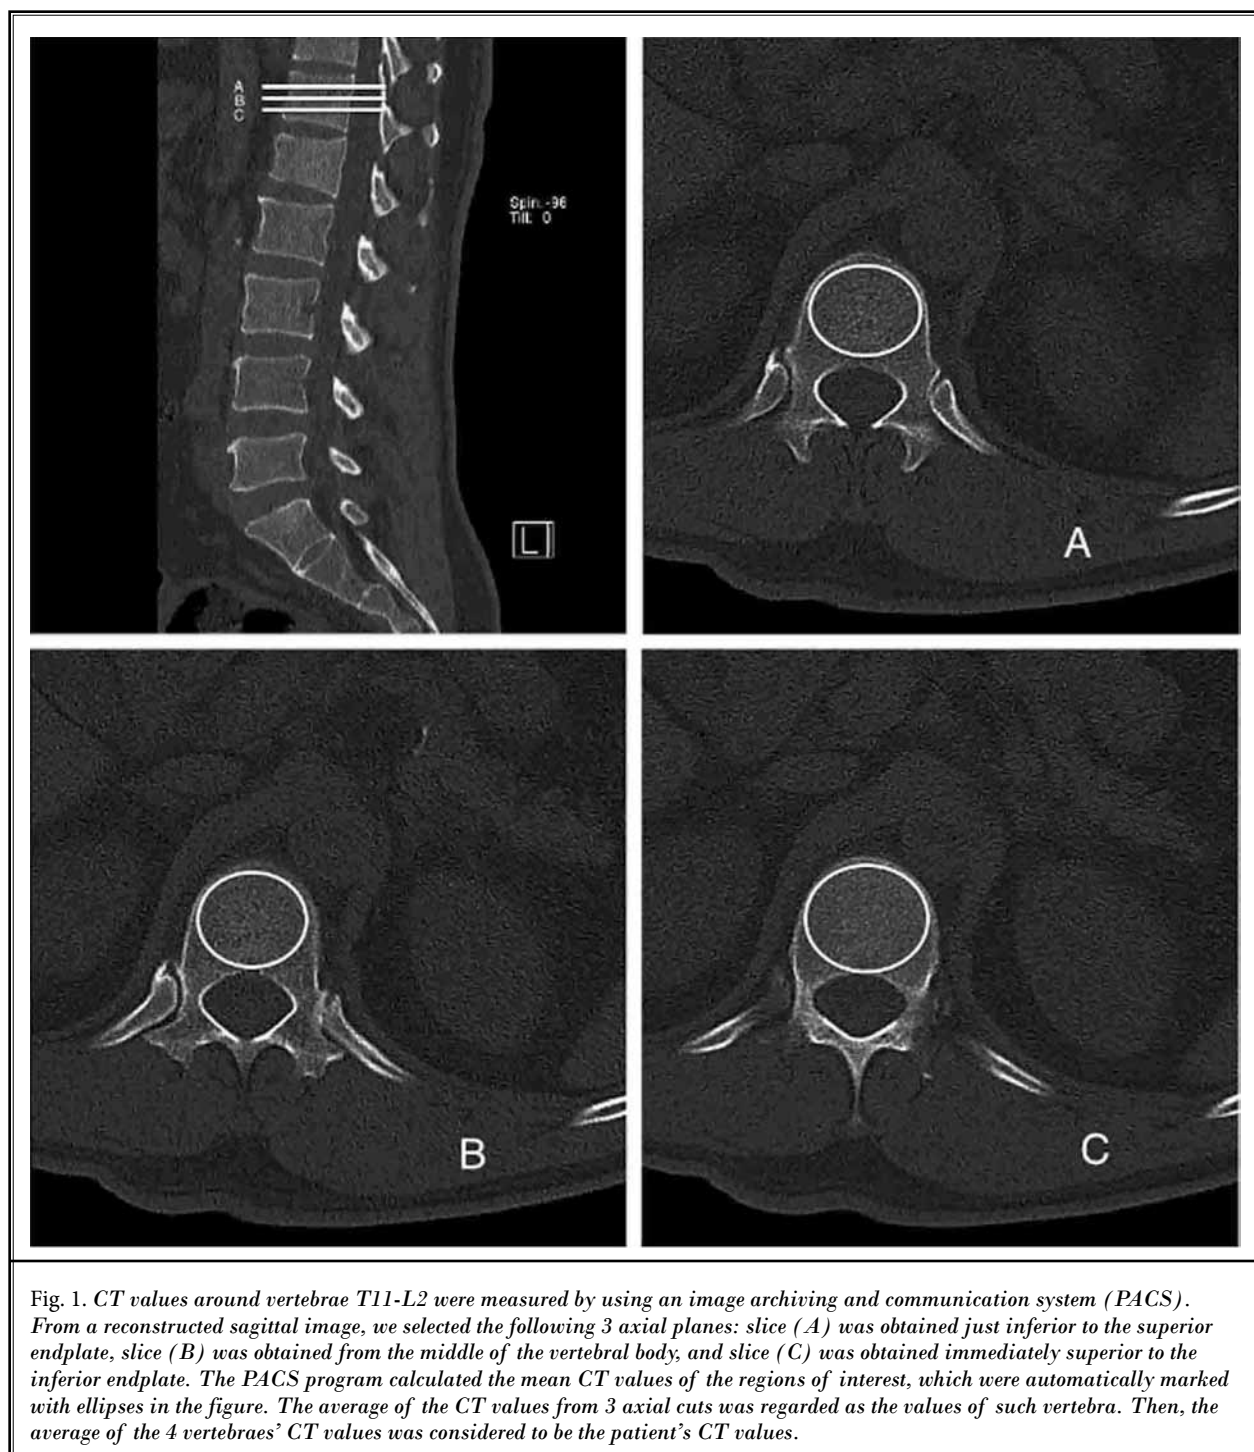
CT values around vertebrae T11-L2 were measured by using an image archiving and communication system (PACS). From a reconstructed sagittal image, we selected the following 3 axial planes: slice (A) was obtained just inferior to the superior endplate, slice (B) was obtained from the middle of the vertebral body, and slice (C) was obtained immediately superior to the inferior endplate. The PACS program calculated the mean CT values of the regions of interest, which were automatically marked with ellipses in the figure. The average of the CT values from 3 axial cuts was regarded as the values of such vertebra. Then, the average of the 4 vertebraes' CT values was considered to be the patient's CT values.
